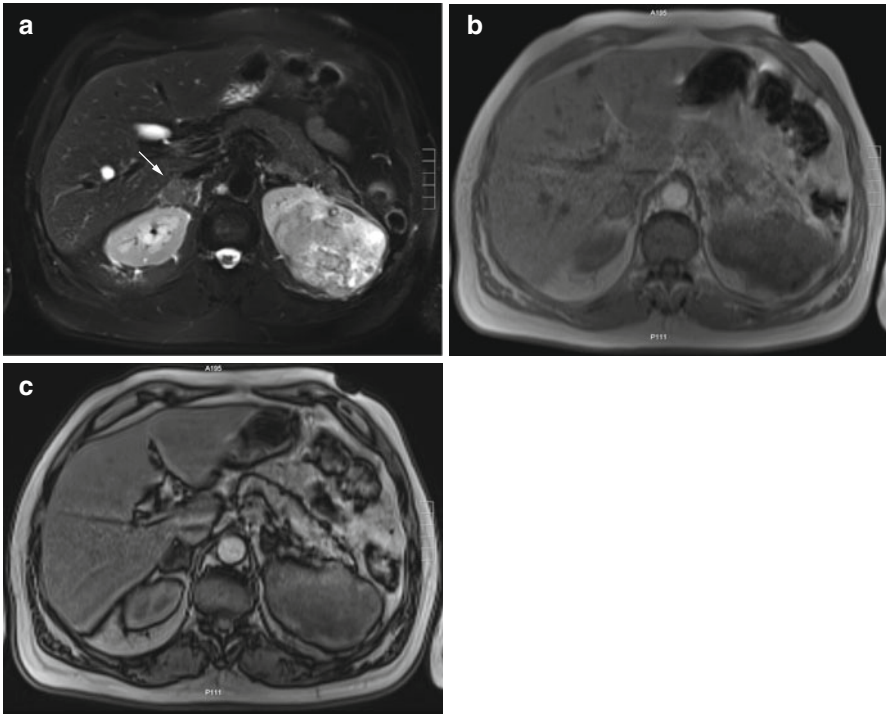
A 63-year-old male subject without symptoms at the time of whole-body screening MRI. (a) Fat-saturated T2w TSE image depicts a heterogeneous mass with central necrosis in the left kidney. The appearance is suspicious for renal cell carcinoma. In addition, a homogeneous mass isointense to muscle is demonstrated in the right adrenal gland (*arrow*). Chemical shift imaging allows discrimination between metastasis and adenoma. The adrenal mass has a signal intensity of 251 (AU) on the inphase image (b) and of 36.3 (AU) on the out-of-phase image (c), ruling out metastasis
